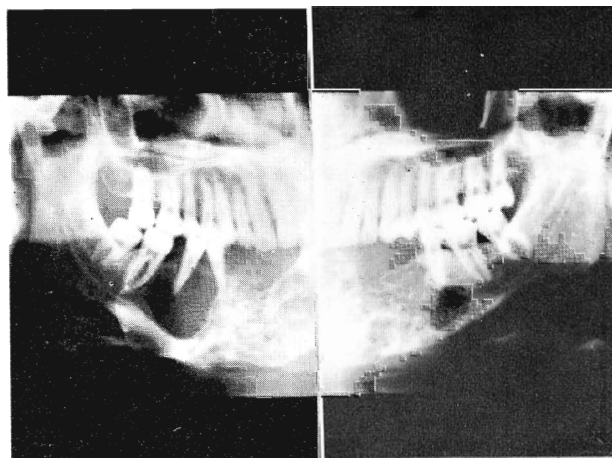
Panorex radiograph showing a large osteolytic lesion of the symphysis and body of the mandible.
